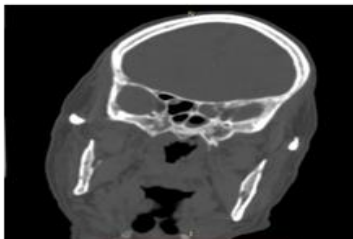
Coronal CT showing type IV optic nerve on the right (arrow)-The nerve course lies immediately adjacent to the sphenoid and posterior ethmoid sinus.
